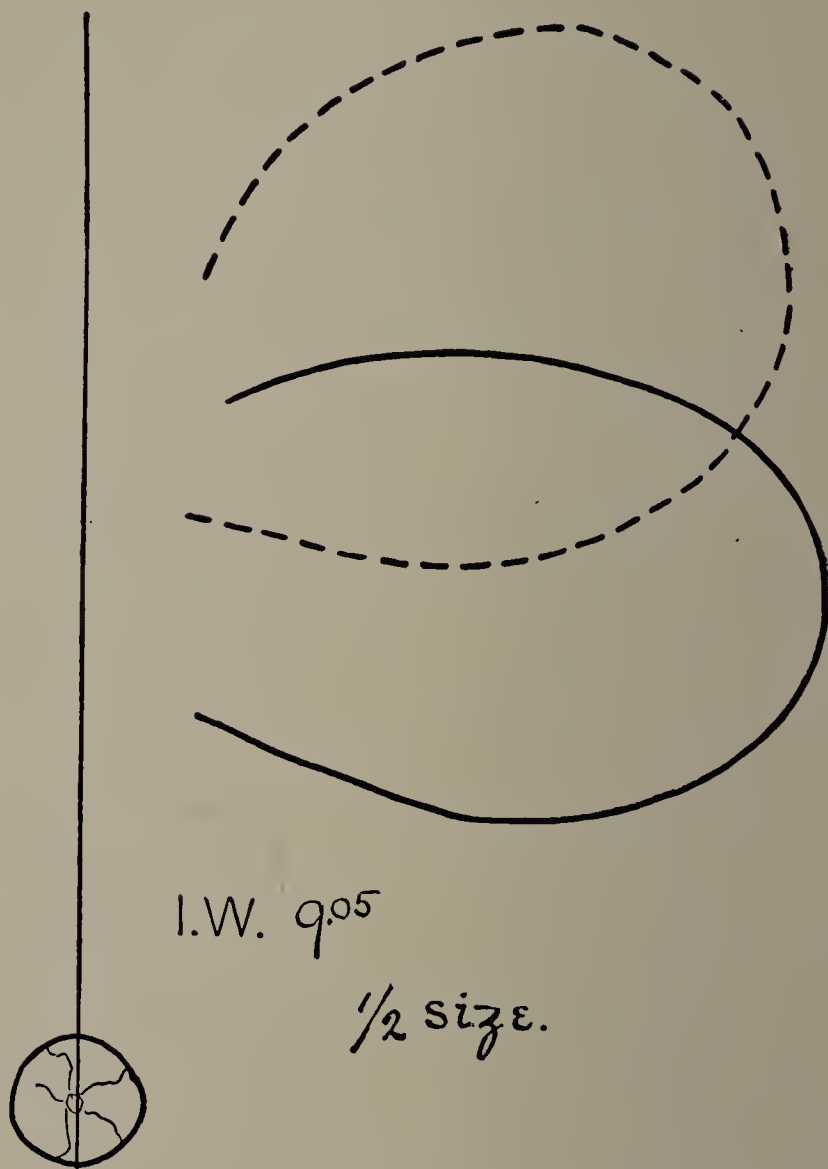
James W. Cut of X-ray tracing. 9.05 P.M. Broken line shows size and position of stomach in expiration; full line, in deep inspiration.
